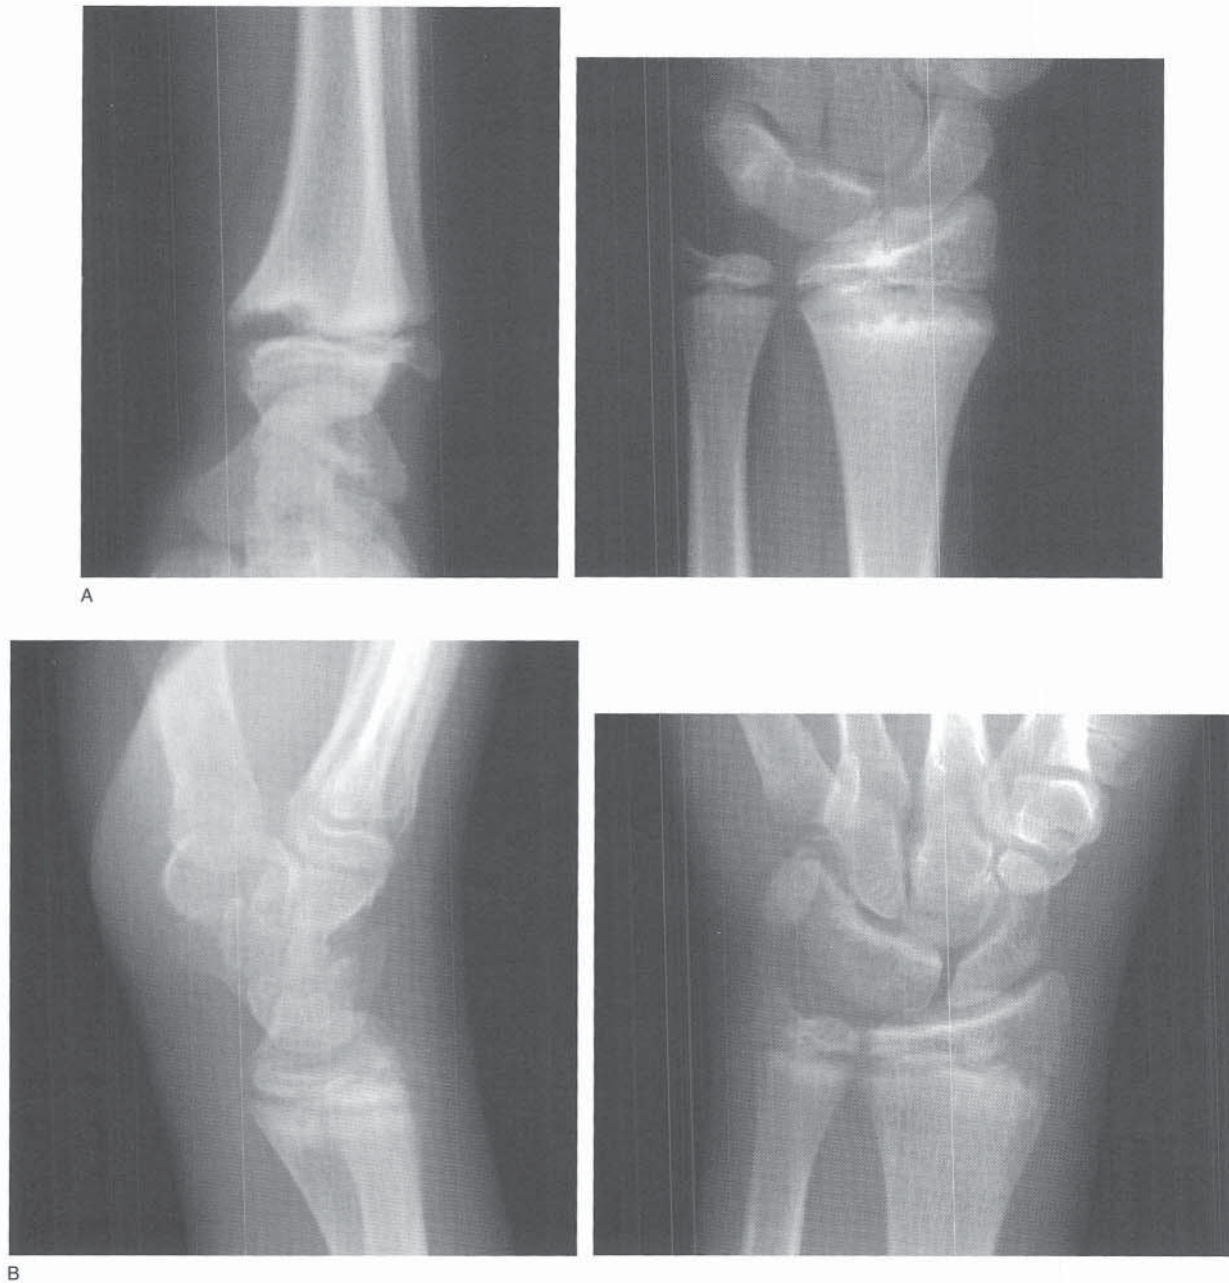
Chronic overuse injury to the distal radial physis. A, AP and lateral radiographs of the right wrist of a 13-year-old gymnast. Note the wide and irregular appearance of the physis. B, The radiographic appearance 3 years later, after cessation of gymnastics.
